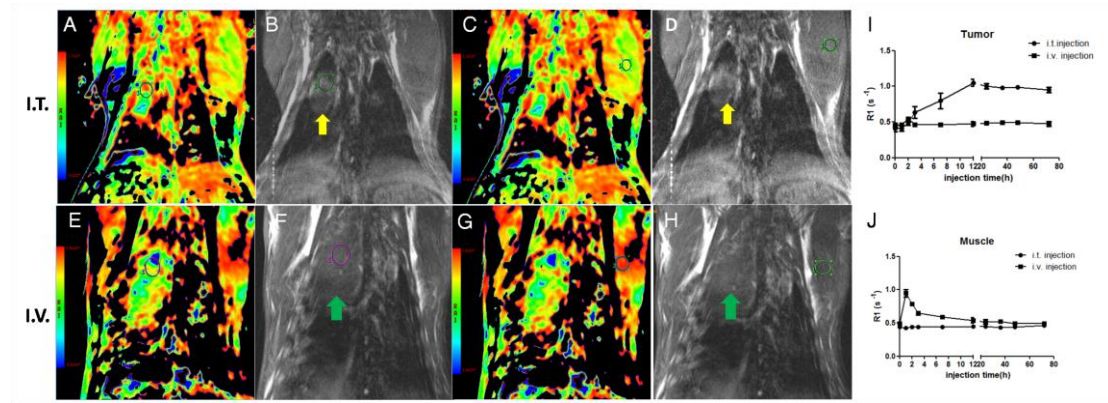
Representative images of *in vivo* ¹H-MRI after I.T. and I.V. delivery of M-PFC NPs. (A,B) R₁ color mapped MR images; T₁-weighted MR images of the same ROI of tumor; (C,D) R₁ color mapped MR images; T₁-weighted MR images of the same ROI of muscle; (E,F,G,H) R₁ color mapped MR images; T₁-weighted MR images of the same ROI of tumor and muscle, respectively.
